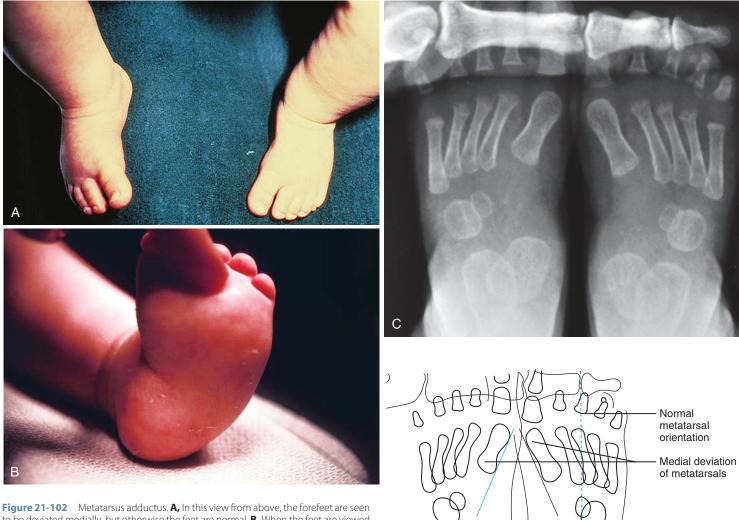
Metatarsus adductus. A, In this view from above, the forefeet are seen to be deviated medially, but otherwise the feet are normal. B, When the feet are viewed from the plantar aspect, rounding of the lateral border can be appreciated, along with a crease on the medial side. C, In the anteroposterior radiograph, all five metatarsals can be seen to be deviated medially with respect to the remainder of the foot; otherwise, the bony structures are normal. The relationship of the talus and os calcis is normal, unlike the relationship in clubfoot.
